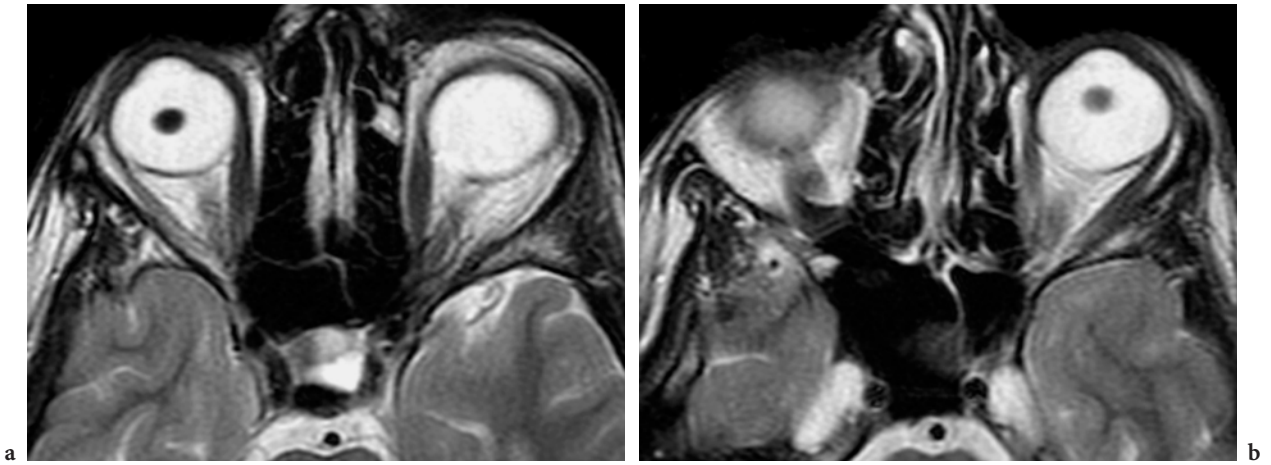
Lens dislocation in homocystinuria (cystathionine β -synthetase deficiency). a, b Axial T2-weighted fast spin-echo images in a 19-year-old female patient with homocystinuria. Posterior dislocation of the lens bilaterally
